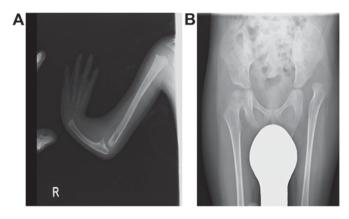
Skeletal anomalies of case 3 revealed by X-ray examination. Right radial ray defects; (A) absent radius and absent thumb. (B) Left hip dislocation.
